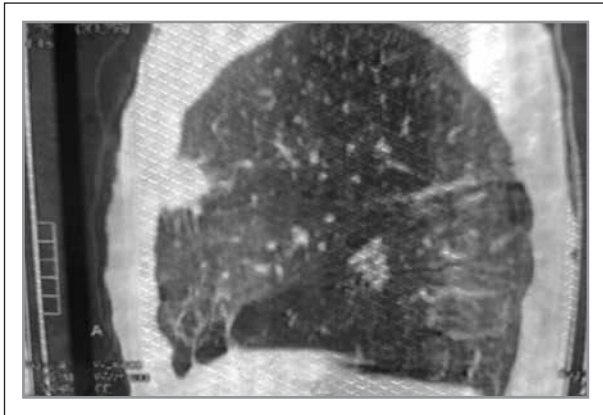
Photo was showing CT chest with small peripheral lung nodule and emphysematous lung
